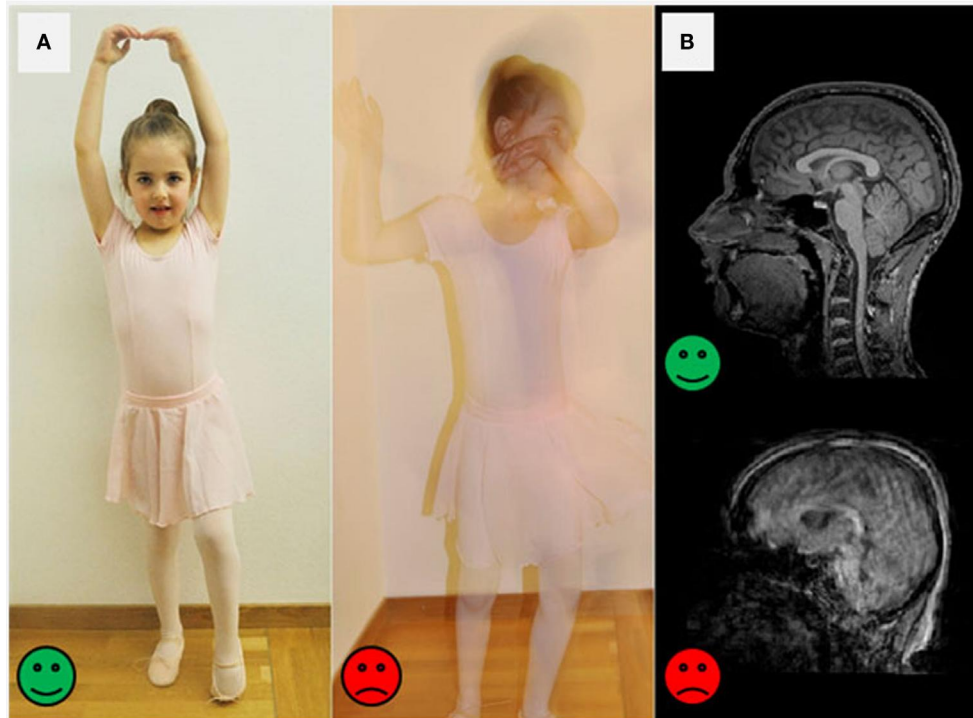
Why staying still during an MRI session is important: [A] A picture taken by a regular camera can be very sharp when the person is standing super still (green happy face). But when the person is moving a lot, the picture becomes blurry (red sad face). [B] The same is true when taking brain pictures. The pictures can turn out super sharp when the person stays still (green happy face) or blurry and hard for scientists to read for when the person wiggles around (red sad face).
